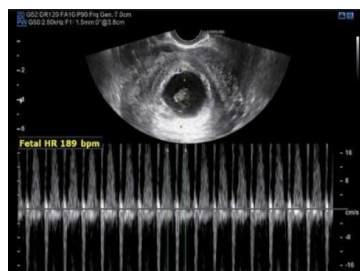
Transvaginal Sonography : Subchorionic hematoma
